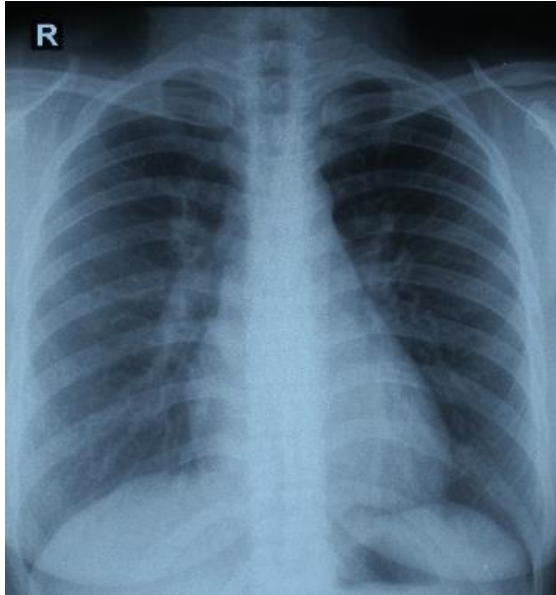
Chest X-Ray control after treatment was normal
